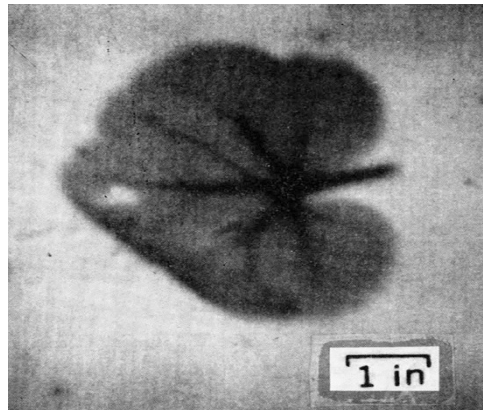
Radiography of a leaf obtained with a proportional chamber.
